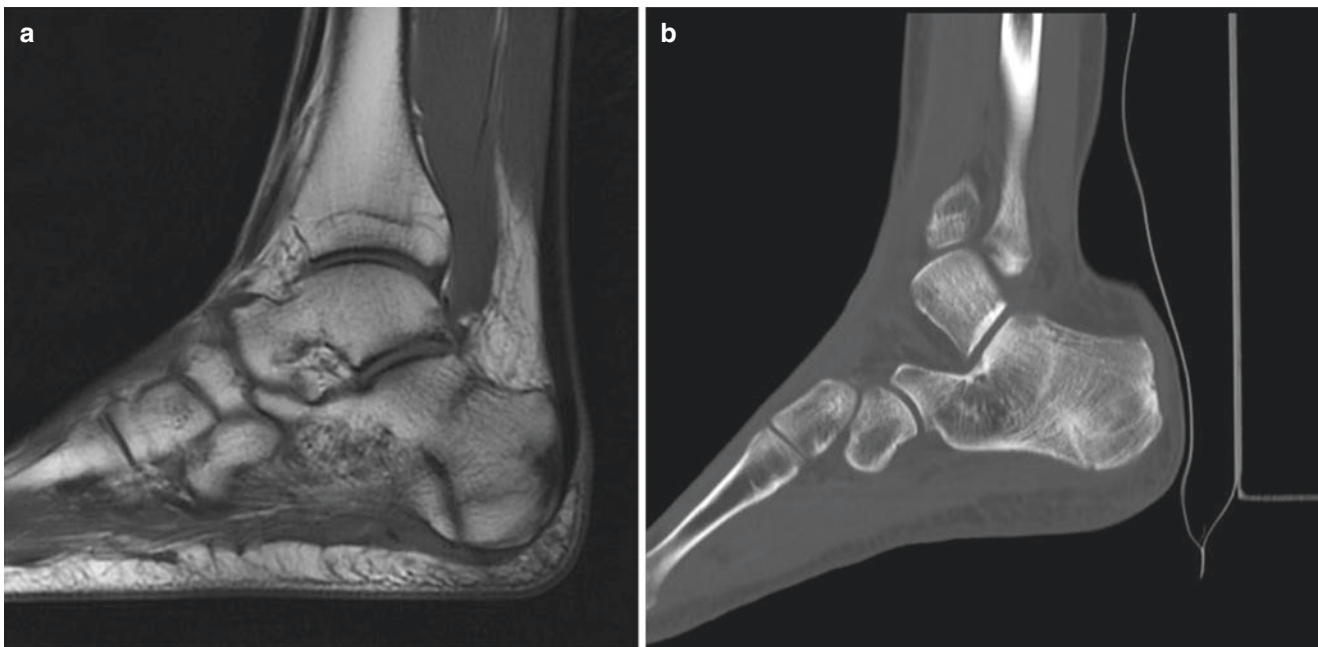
(a) MRI of patient with calcaneal stress fracture; note fracture lines also perpendicular to plantar fascia, which is thickened. (b) CT of same patient after undergoing dry-needling for “plantar fasciitis” which created an inferior fracture
